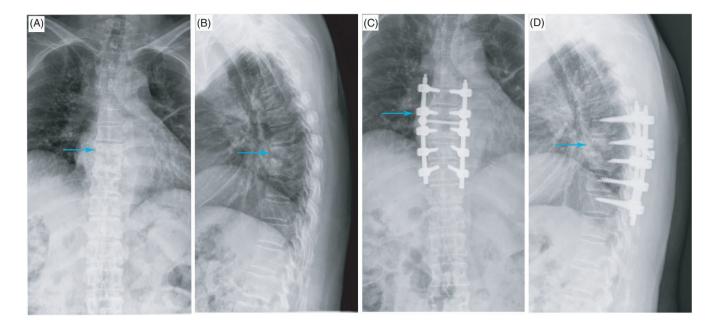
Preoperative and postoperative X-ray examinations during the first surgery in March 2019. (A) The arrow points to the preoperative T7 focal vertebral body in the coronal plane. (B) The arrow points to the preoperative T7 focal vertebral body in the sagittal plane. (C) The arrow points to the postoperative T7 focal vertebral body in the coronal plane. (D) The arrow points to the postoperative T7 focal vertebral body in the sagittal plane.
